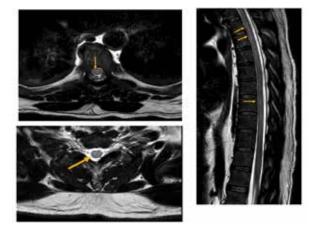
Axial and sagittal T2 weighted images of MRI of the dorsal spine, demonstrate subtle continuous long high signal intensity in the ventral horn of the grey matter in the upper and mid thoracic cord at T4 to T8 level (arrows), with no post IV contrast enhancement; findings represent viral myelitis.
